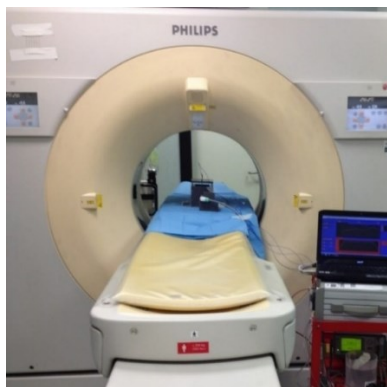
Computed tomography scanner: Brilliance iCT System, Philips Medical System technologies.
